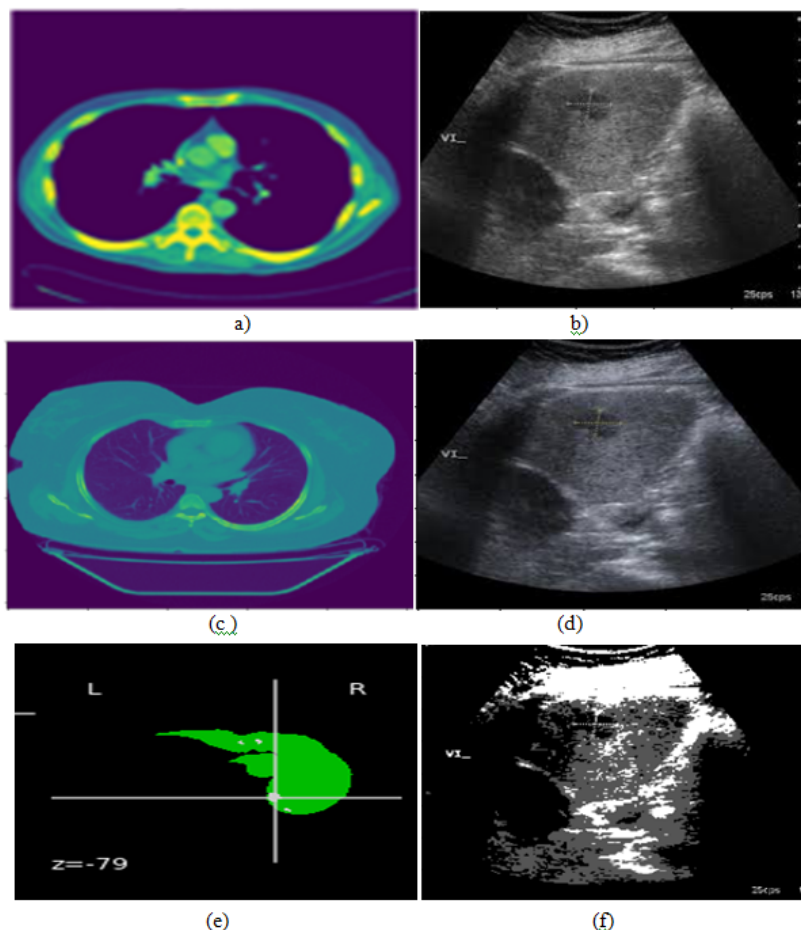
(a) and (b) –Noisy Liver Images (c) and (d)De-noise images (e) and (f) Segmented Liver Images of CT and US images respectively
